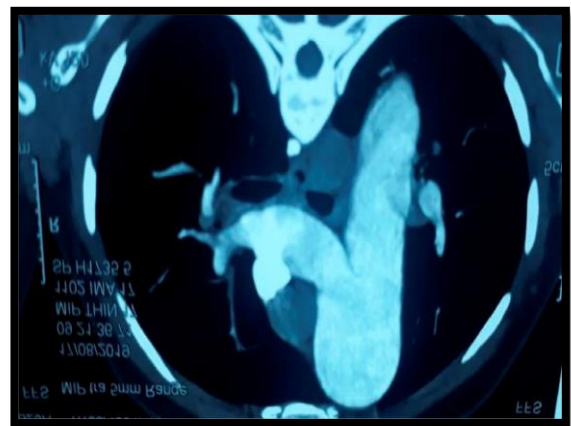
Computed tomography thorax showed right atrial, right ventricular and pulmonary arterial dilatation (PA diameter 41 mm, PA / Ascending aorta diameter ratio was 1.57) with no evidence of thrombus.
